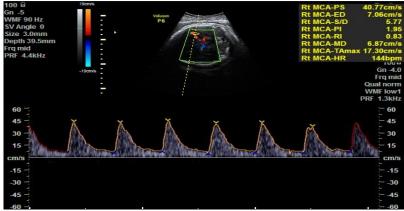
Case 1, MCA Doppler showing normal waveform and Doppler indices (RI=0.83, PI=1.95).
